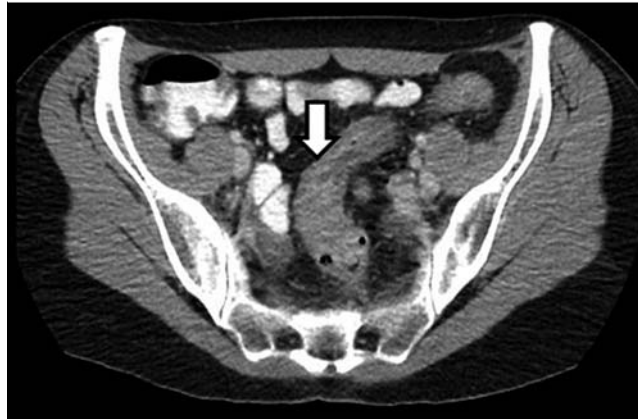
Oral and intra-venous contrast-enhanced computed tomography (CT) image (axial view) showing diffuse and irregular thickening of the wall of the sigmoid colon.
